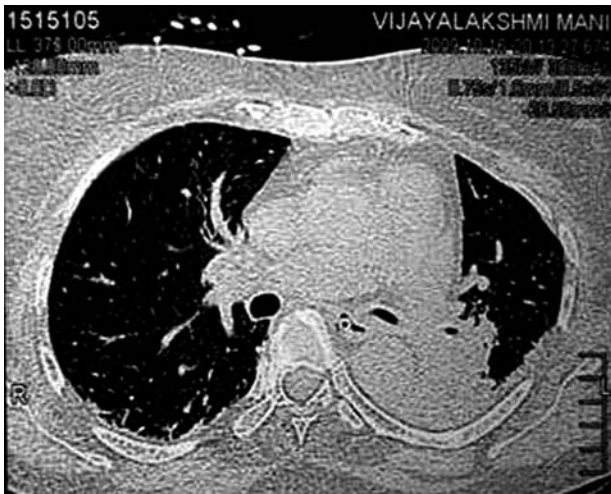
Computed tomography of chest (lung window) showing left lower lobe consolidation.
